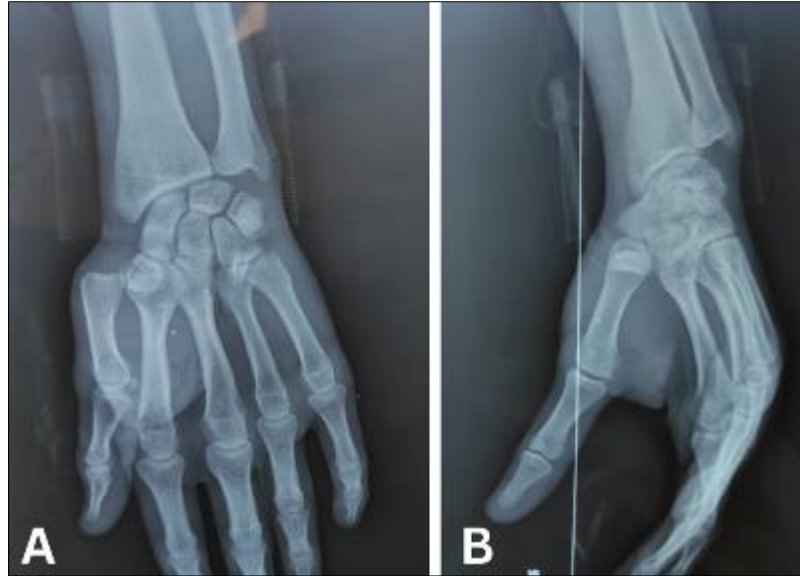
(A+B) Preoperative radiographs showing a pure dorsale trapezio-metacarpal joint dislocation
